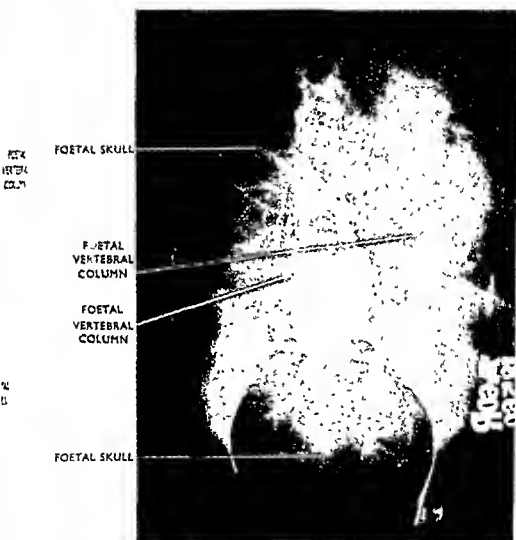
The antero-posterior radiograph of the abdomen of an expectant mother.
